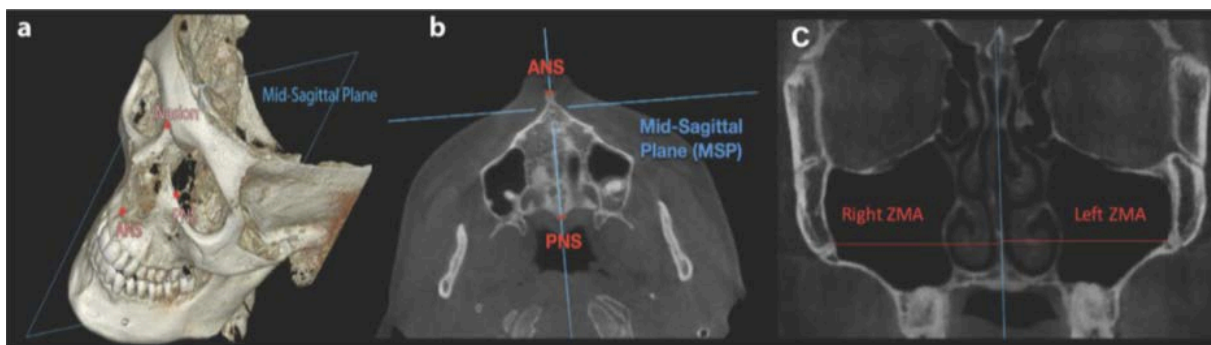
Study by Elkenawy: a CBCT image showing mid-sagittal plane (MSP) on subject's initial CBCT using OnDemand (Cybermed, Korea). ANS, PNS, and nasion can be viewed as separate skeletal landmarks on the MSP. b Axial slice at pre-expansion with vertical line passing through ANS and PNS. c Coronal view of pre-expansion CBCT displaying measurements from the MSP to both the right and left ZMA. Right and left ZMA landmarks indicated in red at the most medial-superior location of the zygomatic-maxillary suture
